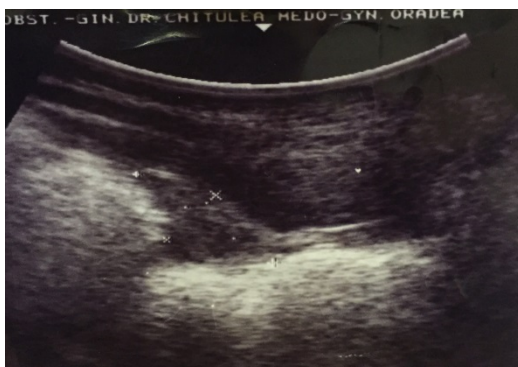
The ultrasound performed 2,5years after surgery.
